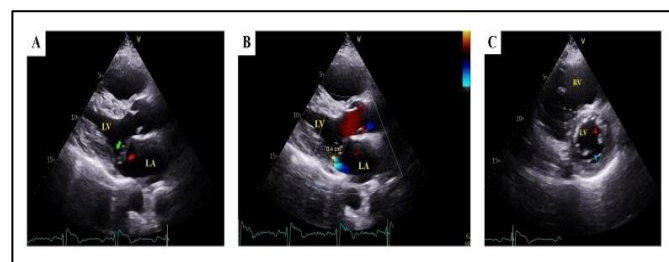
Transthoracic echocardiographic images in parasternal long axis view showing severely hypoplastic posterior mitral leaflet (green arrow) with a myxomatous, elongated and prolapsing anterior mitral leaflet (red arrow) (A), mild to moderate posteriorly directed jet of mitral regurgitation (vena contracta width 4mm) (B), anterolateral papillary muscle (red arrowhead) and posteromedial papillary muscle (blue arrowhead) in parasternal short axis view (C). LA- Left atrium, LV- Left ventricle, RV- Right ventricle
